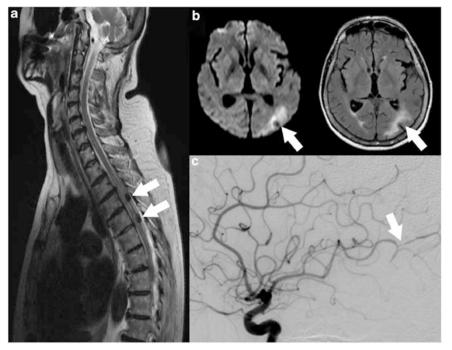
Spinal MRI sagittal T2-weighted images showing two spinal subarachnoid hematomas at T4 and T5 levels and centromedullary hyperintensity at T1–T6 levels (a). Brain MRI (DWI and FLAIR sequences) showing acute left watershed infarction between middle and posterior cerebral artery territories (b). Stenosis of the left posterior temporal branch of the middle cerebral artery is seen on angiography (c).
